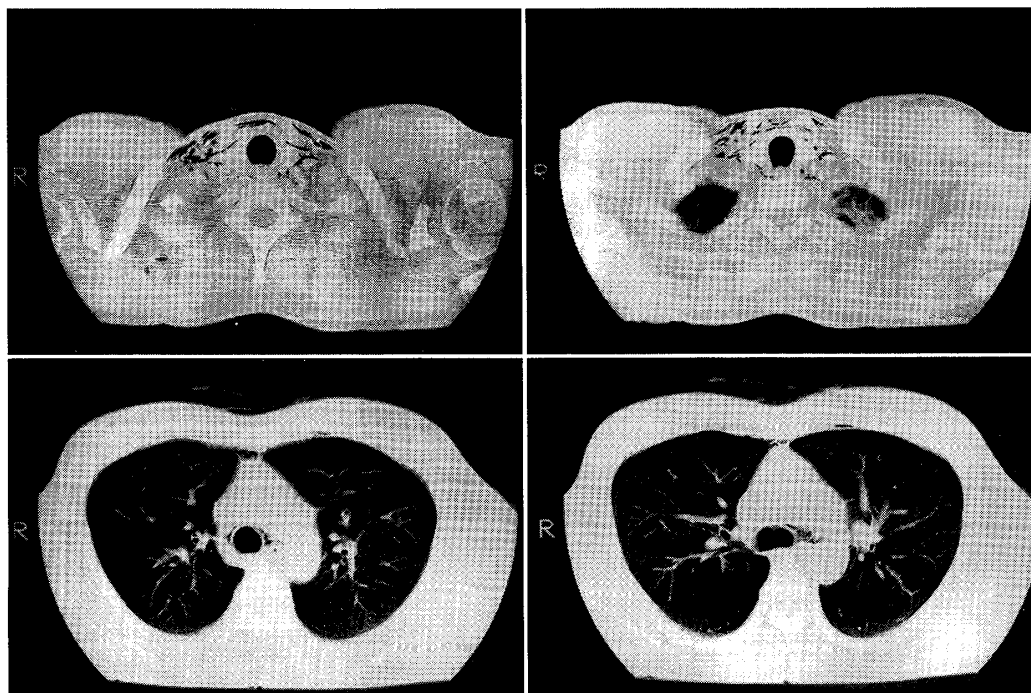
CT scan obtained on admission.
